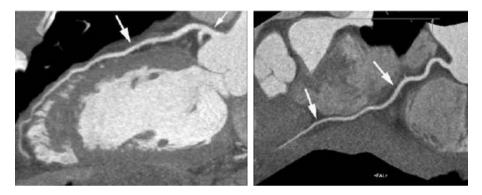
Cardiac scanning at high pitch and 100 kV with dual source CT is possible at submillisievert levels with high image quality, in this case with 0.8 mSv effective dose (courtesy of S. Achenbach, Erlangen) [7].
